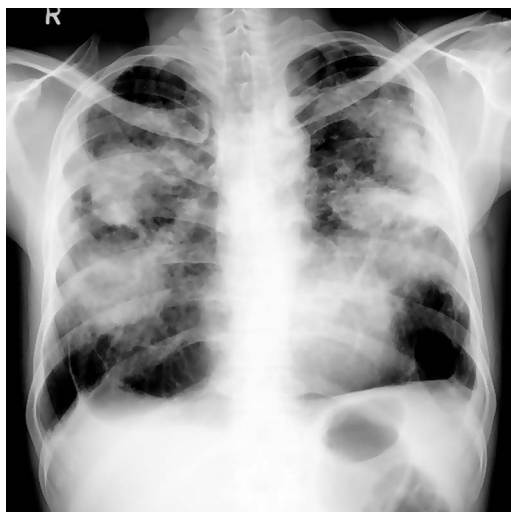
Chest X-ray on presentation showing reticulonodular shadows and multiple mass-like symmetrical lesions with irregular margins. This is known as 'angel's wings' appearance. The lateral interfaces of the mass lesions parallel the lateral chest wall.
